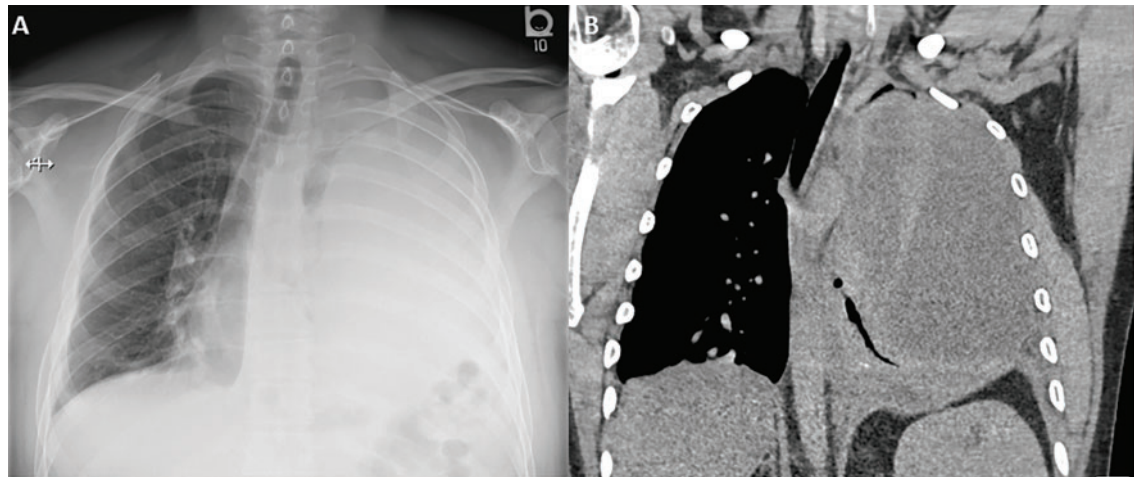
Complete opacification of the left hemithorax on chest radiography (A) and massive pleural effusion causing mediastinal shift to the right on computed tomography (B).
